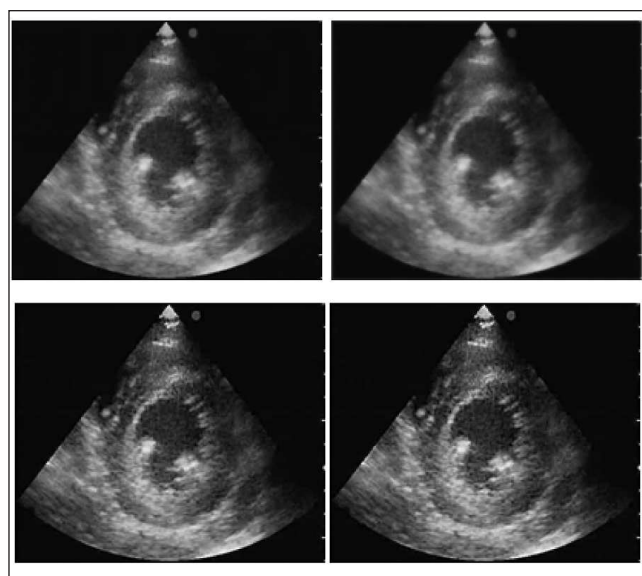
Echocardiogram (upper, leftmost) and filtered replicas for different values of parameter α .
